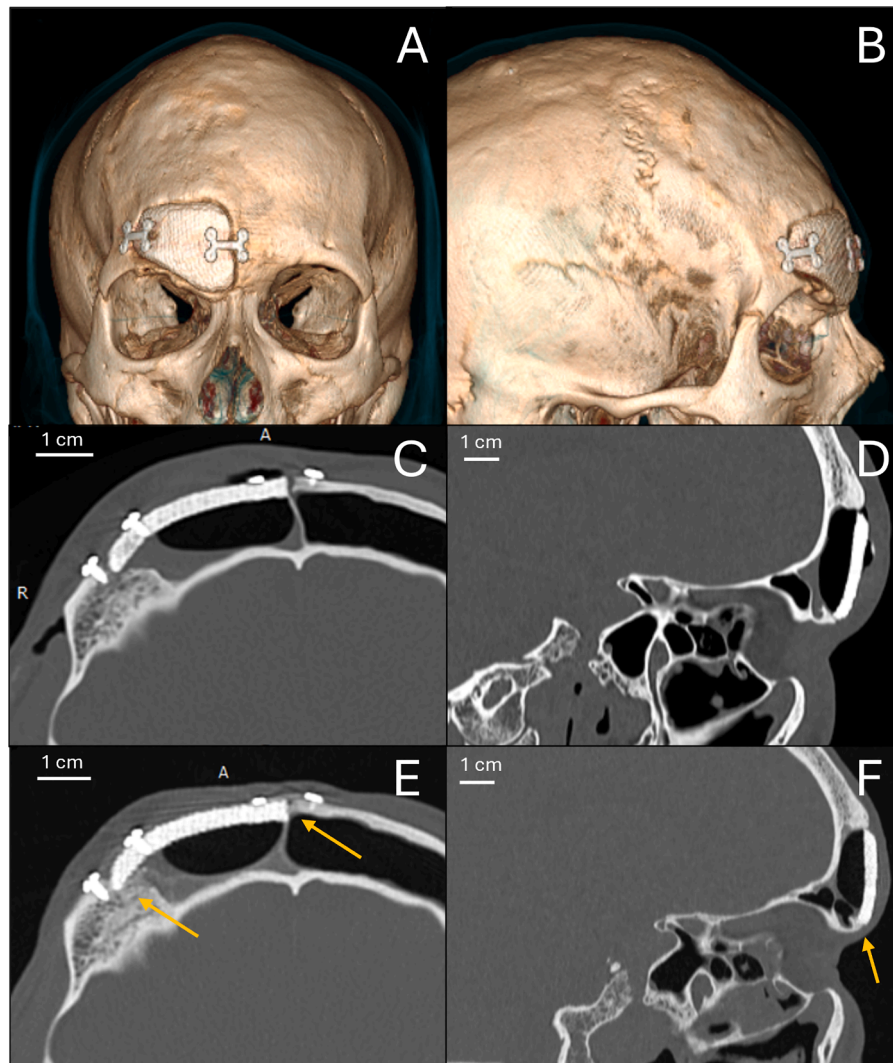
Postoperative follow-up – (A) & (B) 3D frontal and side views of the postoperative situation.; (C) & (D) 1-day post-operative CT scan, axial and sagittal views respectively; (E) & (F) 6-month post-operative CT scan, axial and sagittal views respectively; arrows are pointing to the osteointegration signs.
